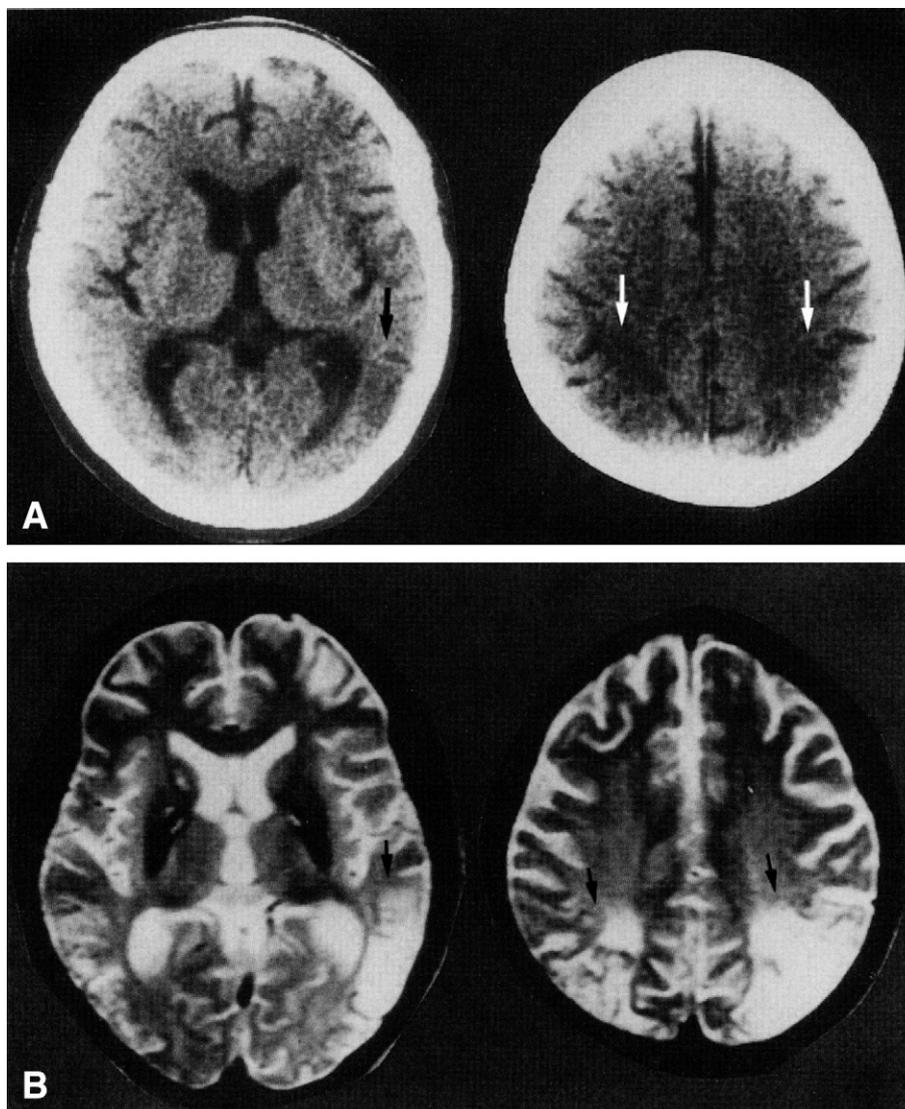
Brain CT and MRI scans in the same patient. (A) CT findings. The arrows show low-density areas. (B) T2-weighted MRI cortical areas are more affected than the subcortical areas from Murata et al. [20].
